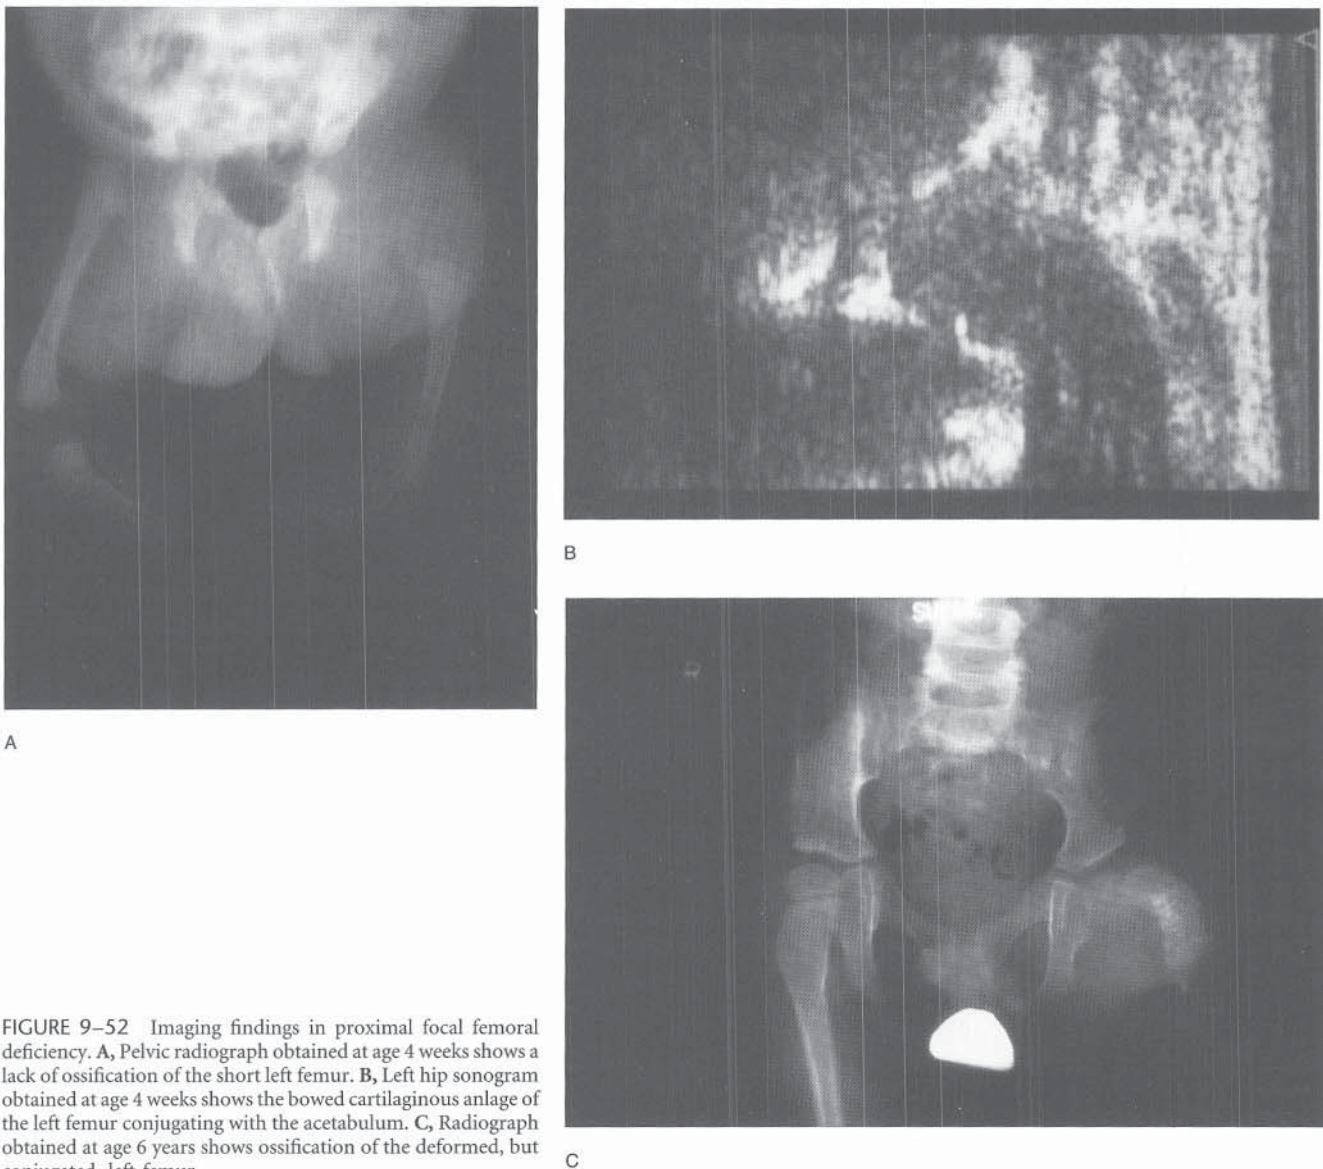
Imaging findings in proximal focal femoral deficiency. A, Pelvic radiograph obtained at age 4 weeks shows a lack of ossification of the short left femur. B, Left hip sonogram obtained at age 4 weeks shows the bowed cartilaginous anlage of the left femur conjugating with the acetabulum. C, Radiograph obtained at age 6 years shows ossification of the deformed, but conjugated, left femur.
